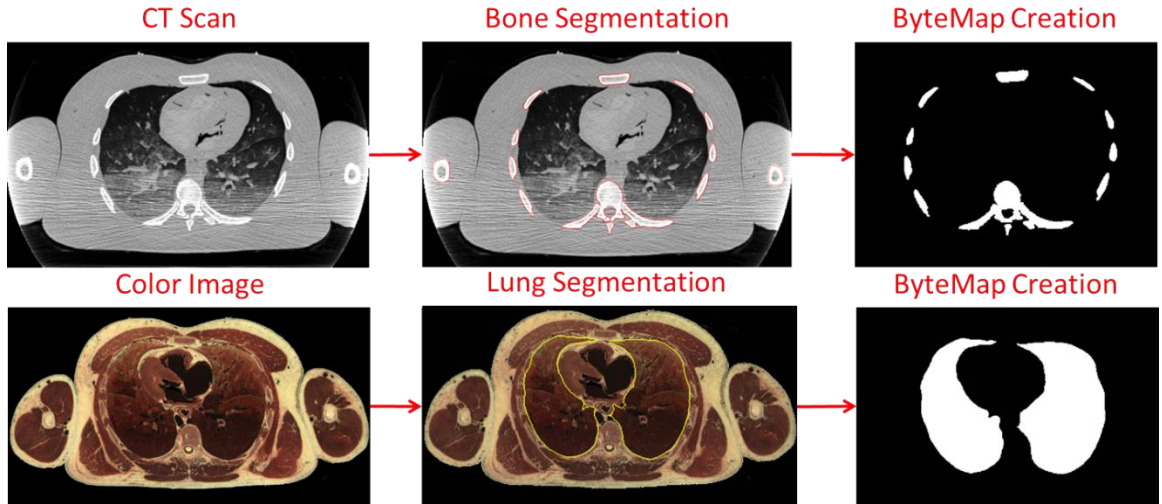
Segmentation technique. Top Row: Segmentation of bone material from CT scan, inferior to superior slice orientation – image right is body left. Bottom Row: Segmentation of lung material from high resolution color images of cryosections, superior to inferior orientation–image right is body right.
